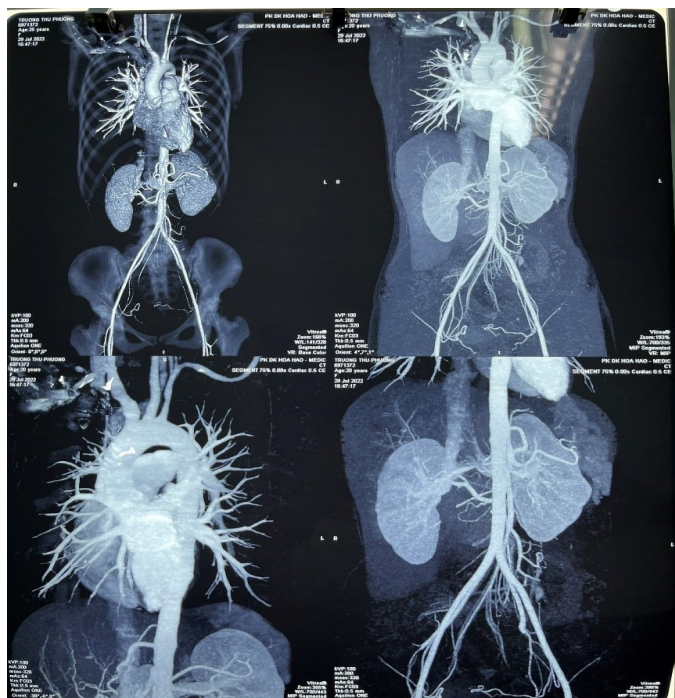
Chest and abdomen aortic CT scan with contrast showed stenosis of the right brachiocephalic artery, left common carotid artery, 50% stenosis of the left subclavian artery and 60% stenosis of the right renal artery.
